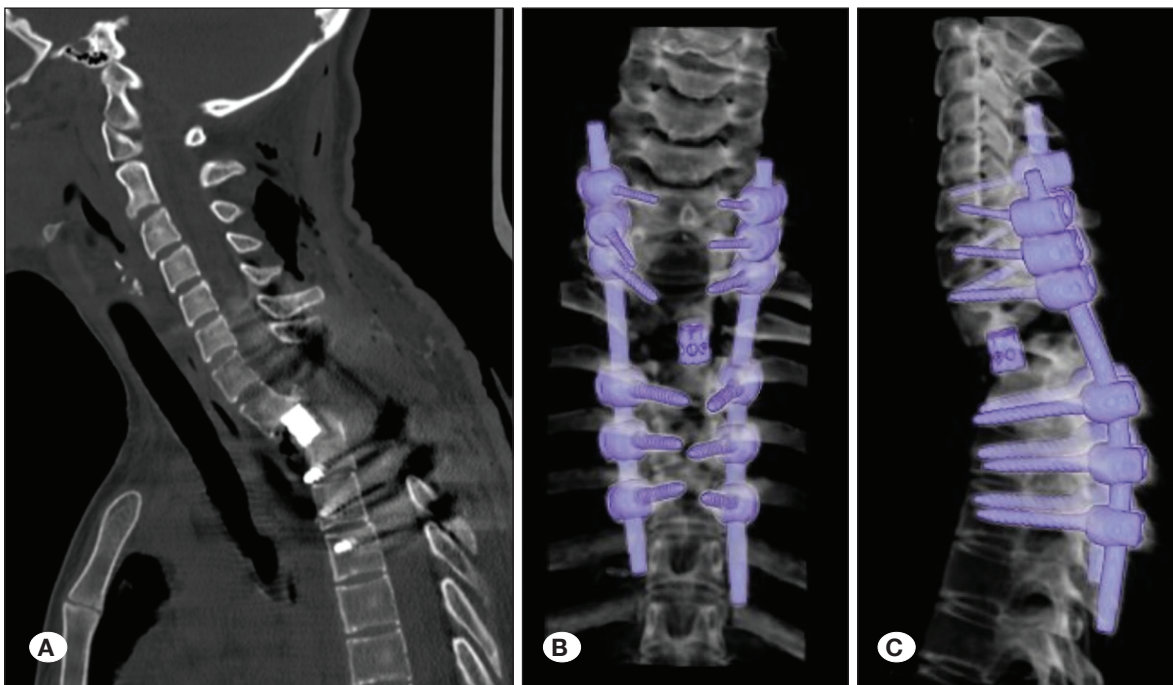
Postoperative images. A) Postoperative computed tomography (CT) images showing the cage in place. B) Postoperative 3D CT showing the cage and implanted screws on anteroposterior images. C) Postoperative 3D CT showing the cage and implanted screws on lateral images.
